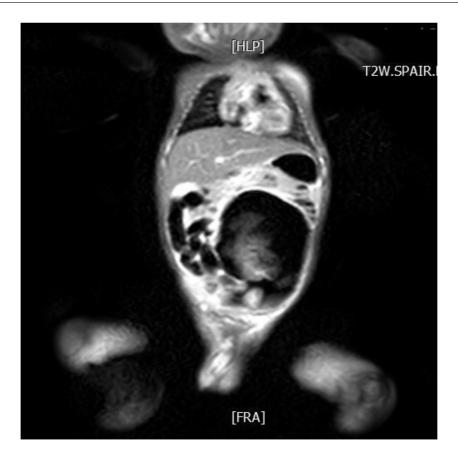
MRI anterior view showing a well encapsulated mass containing large amount of gas, compressing and displacing the small intestines forward.
